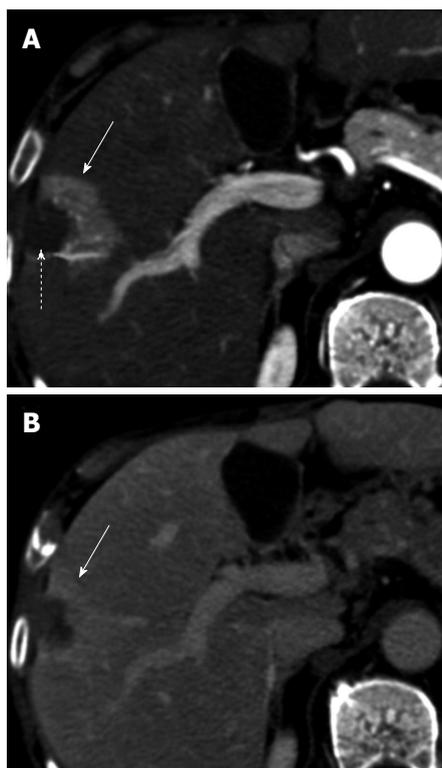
Perfusion alteration after radiofrequency ablation for hepatocellular carcinoma. A: Arterial phase computed tomography (CT) obtained 1 mo after treatment shows ablated zone (dotted arrow) and a semilunar enhancing area (solid arrow) medial and anterior to ablated zone; B: Delayed phase CT shows persistent enhancement of the semilunar area (solid arrow), suggesting that the arterial enhancement is due to perfusion alteration rather than residual tumor.
